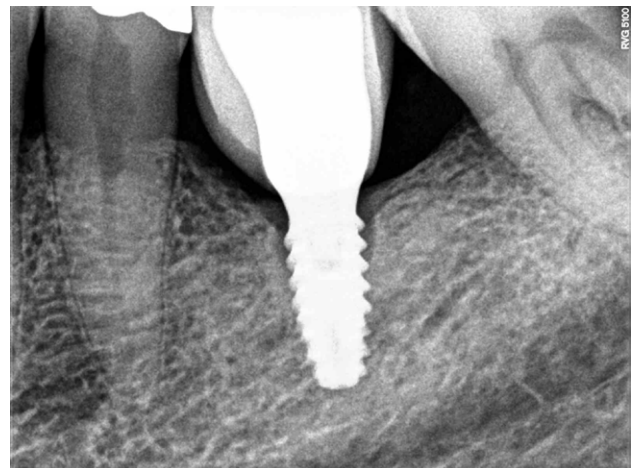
Case 3: Initial periapical x-ray.
